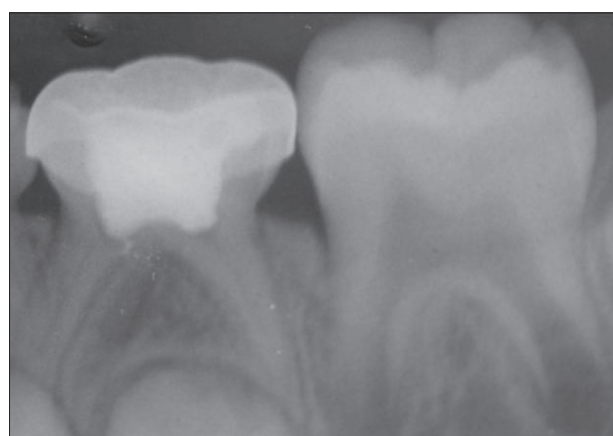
Thirty-six months post-operative radiograph for formocresol pulpotomized tooth (75)
